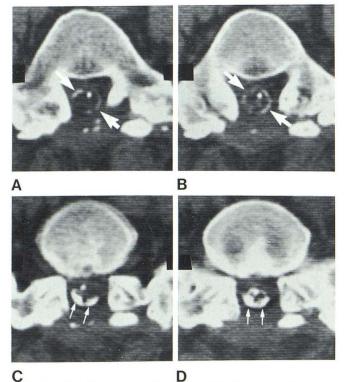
Calcified postoperative arachnoiditis. Severe recurrent radiculopathy 6 months after diskectomy. Myelogram 3 years later showed severe arachnoiditis with narrowed sac at L4–S1. Pain and disability continued. A–D, CT scans 6 years after diskectomy show virtually complete ring calcification of sac (*large arrows*) at L5–S1. Calcification becomes thick and irregular, especially posteriorly in more caudad cuts (*small arrows*). Sac was not calcified at L4–L5 or L3–L4.
